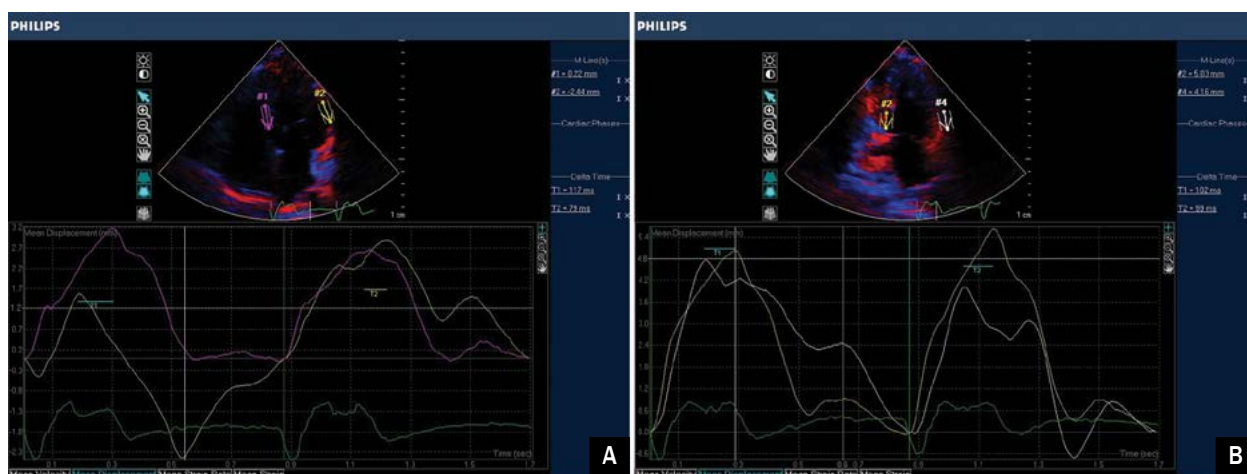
Intraventricular dyssynchrony among patients with right ventricular apical pacing (RVAP) by strain imaging using speckle tracking method: A. Septal to lateral wall delay of 117 ms in apical four-chamber view; B. Anterior to inferior wall delay of 102 ms in apical two-chamber view
